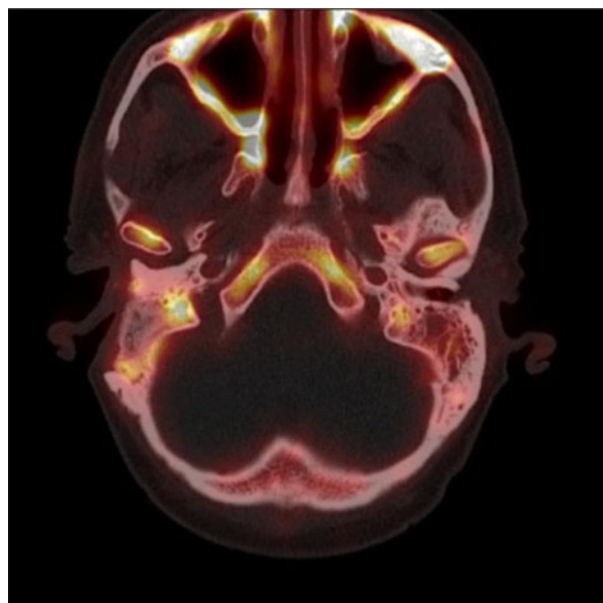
Axial fluorine-18 (18F) sodium fluoride positron emission tomography/computed tomography scan, showing increased uptake of 18F-sodium fluoride on the edges of the obliterated cavity of the right middle ear and mastoid, indicating active bone formation.
